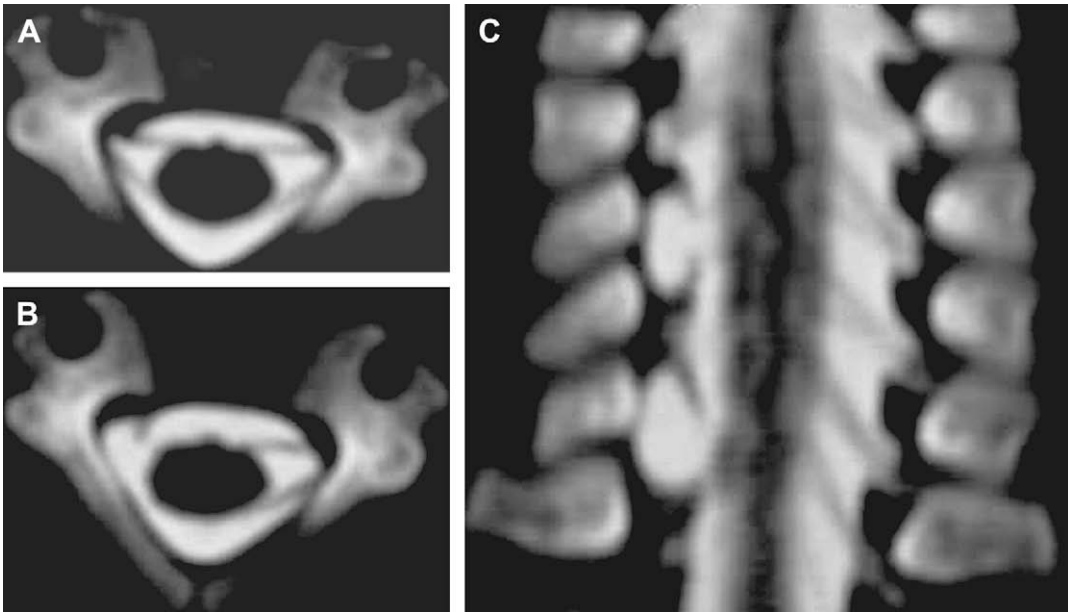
CT myelography. (A) Normal CT myelography. (B) Avulsed root on the right side. Note the absence of root filaments and the small pseudomeningocele. (C) Coronal reconstruction of the CT myelogram demonstrating right-sided pseudomeningoceles.
